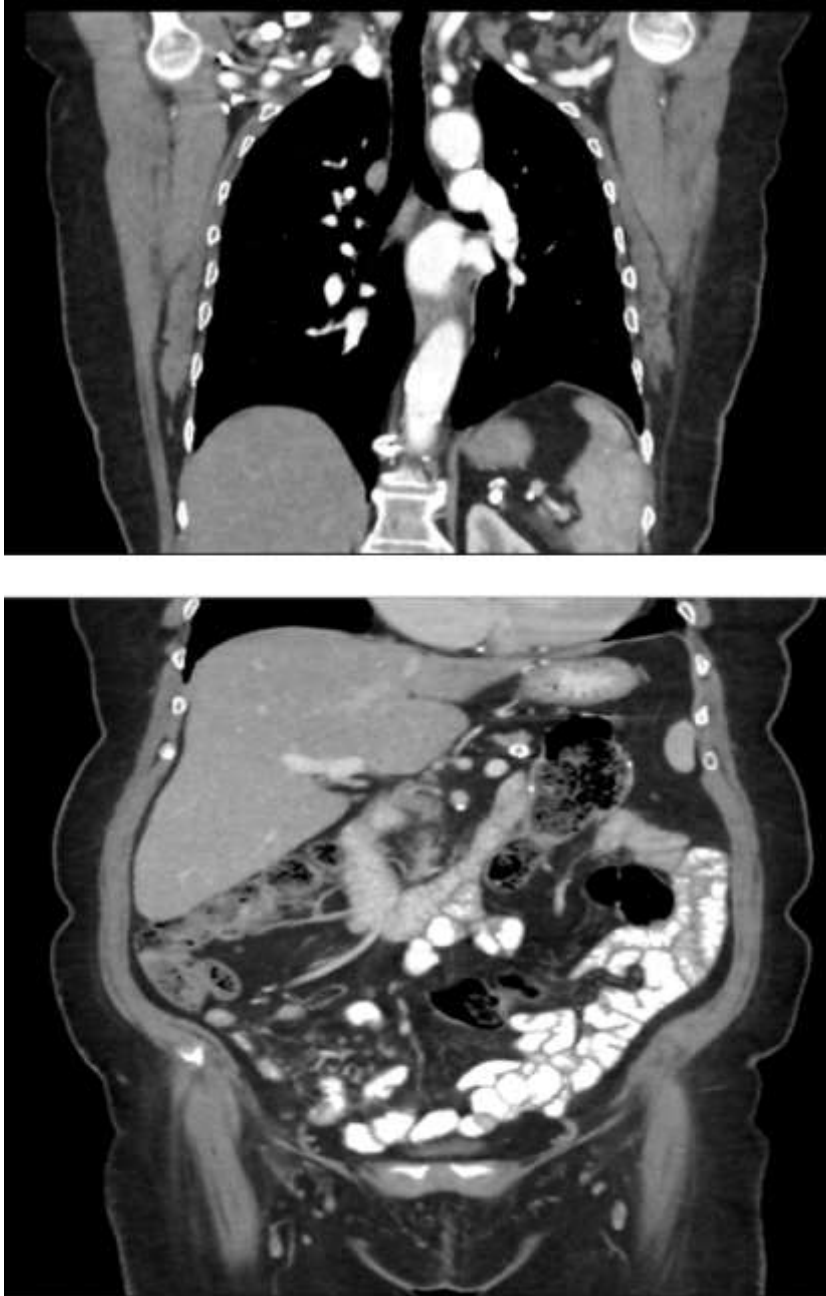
The most recent thorax and abdomen CT
